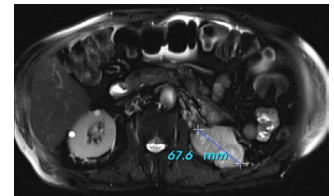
Abdominal MRI: Two mass lesions at the left kidney with heterogeneous enhancement, the large one being 67x42 mm
